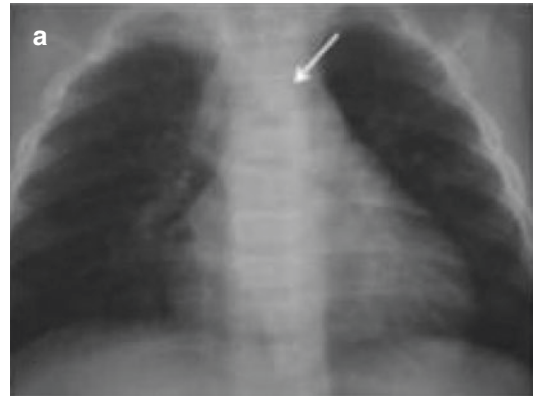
Bronchogenic cysts in a 2-month-old infant with bronchial obstruction syndrome. Chest x-rays in the antero-posterior (a) and lateral (b) views show a mass in the posterior mediastinum that displaces the trachea to the right and anteriorly (*arrows*). (c) An axial CT scan with intravenous enhancement at the carina level confirms a cystic mass that compresses and displaces the trachea anteriorly (*arrow*)
